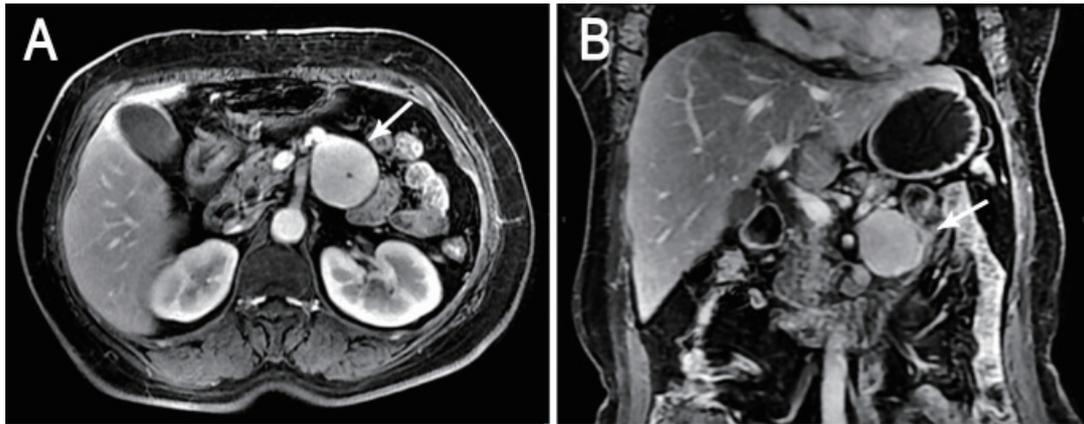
MRI images of the lesion. Abdominal MRI showing a sharply demarcated soft tissue mass located at the inner side of duodenojejunal junction, just beneath inferior border of pancreas, and adjacent to the left side of superior mesenteric artery. The mass was homogeneous and moderately enhanced in arterial phase and portal venous phase.
